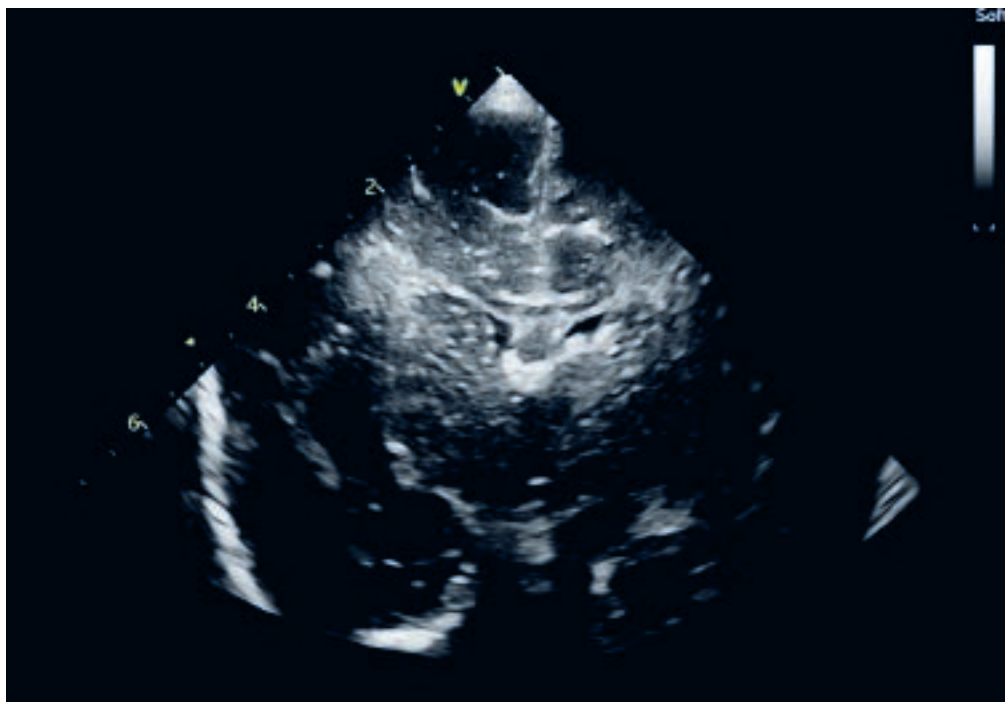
Coronal plane, cranial ultrasonography, at the anterior horns of the lateral ventricle and Sylvian fissures
